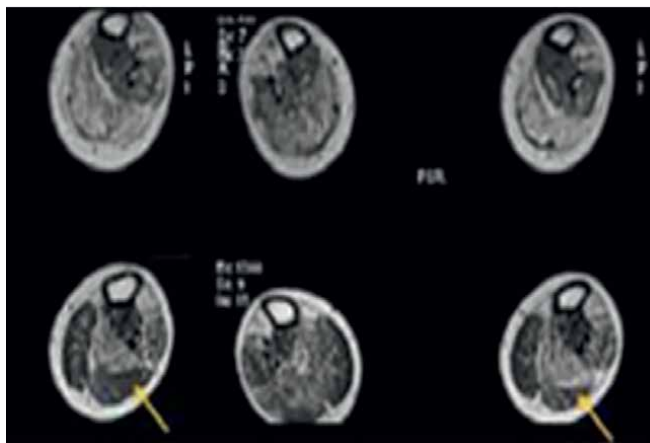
(A) MRI scan of lateral head of gastrocnemius (arrow) pre-cell therapy. (B) MRI scan of lateral head of gastrocnemius (arrow) post-cell therapy showing muscle regeneration.
